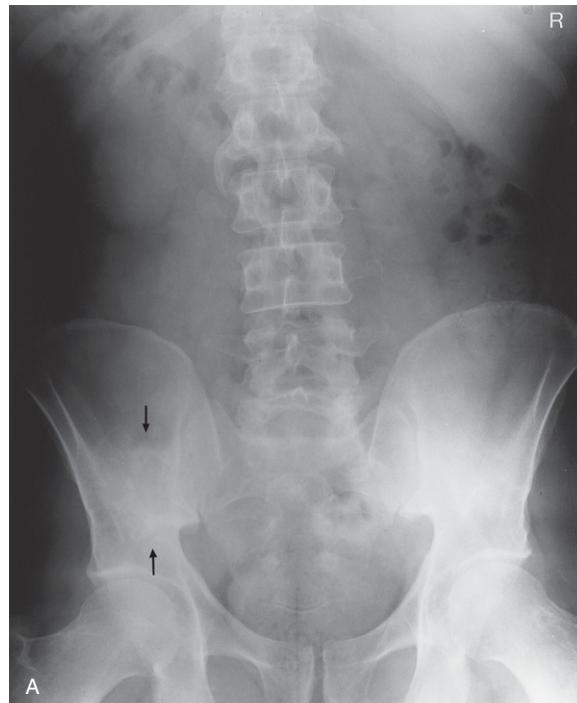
(A) Pelvis and lumbar spine anteroposterior plain X-ray image showing a lytic and sclerotic lesion in the left ilium (Ewing’s sarcoma) (arrows). R = right side of patient. (B) Pelvis anteroposterior plain X-ray image showing previous resection of the ilium and arthrodeses of the left hip. Degenerative changes are noted at the lumbosacral level. No focal bony erosive change is demonstrated.
